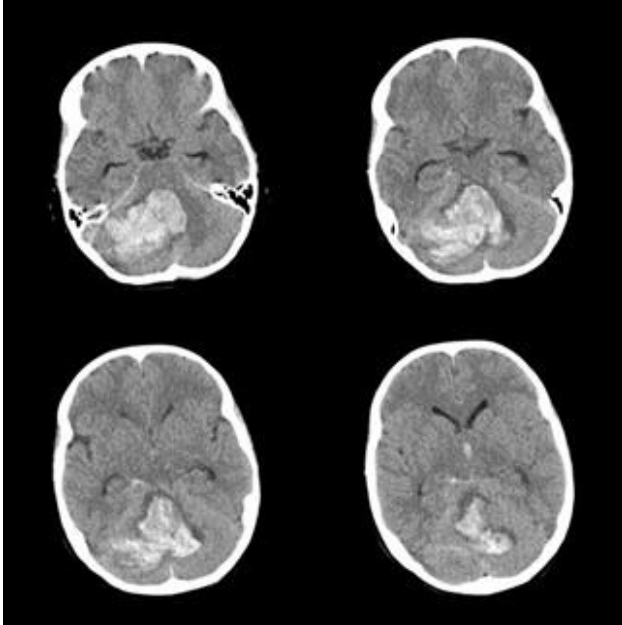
Axial brain CT images. Large amount ICH on the vermis and right cerebellum.
